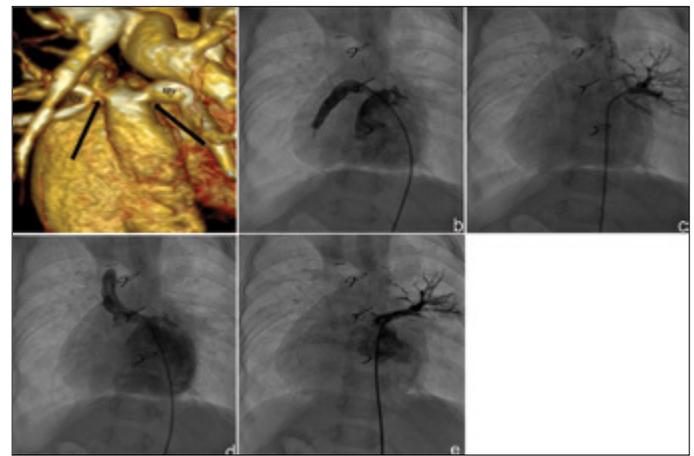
a-e. (a) Posterior volume rendering the multiple detector computed tomography image, (b) posterior–anterior angiographic view of the right pulmonary vein, (c) posterior–anterior angiographic view of the left pulmonary vein, (d) posterior–anterior angiographic view of the right pulmonary vein after stent implantation, and (e) posterior–anterior angiographic view of the left pulmonary vein after stent implantation.
